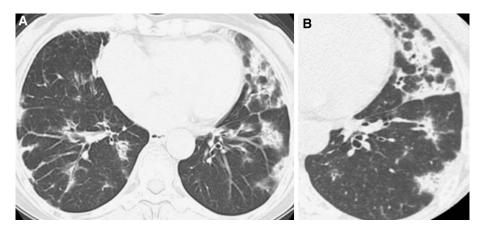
Drug-induced lung injury, organizing pneumonia (OP)-like pattern. Methotrexate (MTX)-induced lung injury (OP-like pattern) in a 73-year-old man with a dry cough and fever who had been treated with MTX for 3 months. (A) Computed tomography (CT) and (B) high-resolution CT, showing multiple foci of consolidation in the subpleural and peribronchovascular regions.
